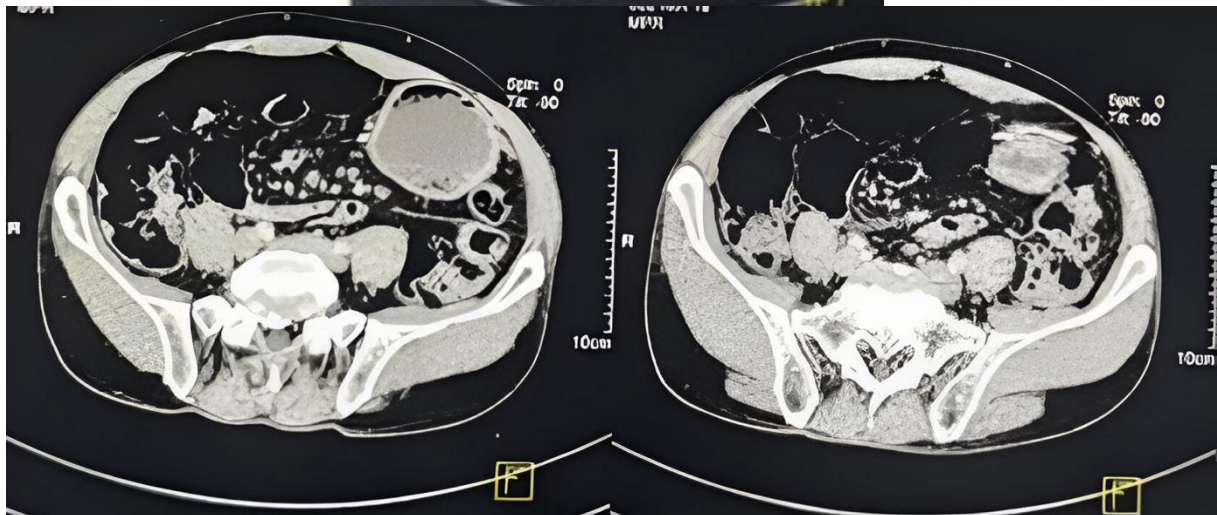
Abdominal CT scan showing marked distension of small bowel loops (up to 45 mm in diameter) with a clear mesenteric “whirlpool sign” in the right iliac fossa, indicating small bowel volvulus. A large pneumoperitoneum is also visible, without evidence of peritoneal effusion.
